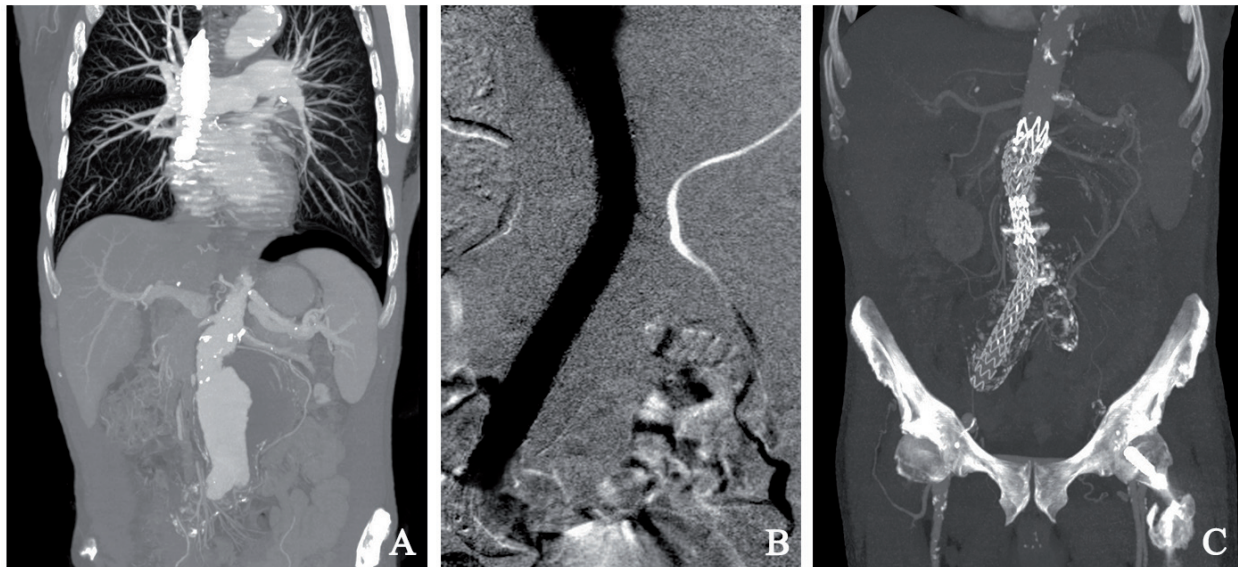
A Multi-planar reconstruction (MPR) computed tomography (CT) showing longitudinal section of contrast filled abdominal aortic aneurysm with bilateral mural thrombus and left pneumothorax with the air layer between the base of the lung and the pleura; B Intraoperative angiogram showing good placement of stent-grafts and absence of any endoleak.; C Postprocedural MPR-CT scan showing complete exclusion of the AAA, no endoleak and patency of the crossover bypass.
